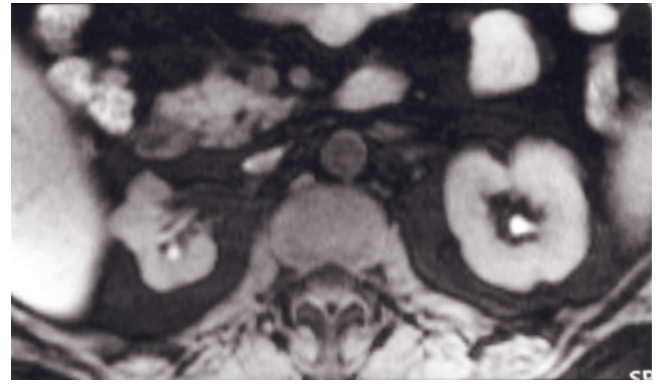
Acute renal vein thrombosis. Coronal (*a*) and transverse (*b*) T2-weighted SS-ETSE and transverse T1-weighted immediate (*c*) and 90-s fat-suppressed (*d*) postgadolinium SGE images. This pregnant patient presented with severe left flank pain. The left kidney is enlarged, and fluid surrounds the collecting system, consistent with edema. Intraluminal clot is appreciated within the left renal vein extending into the IVC (arrows, *d*).
